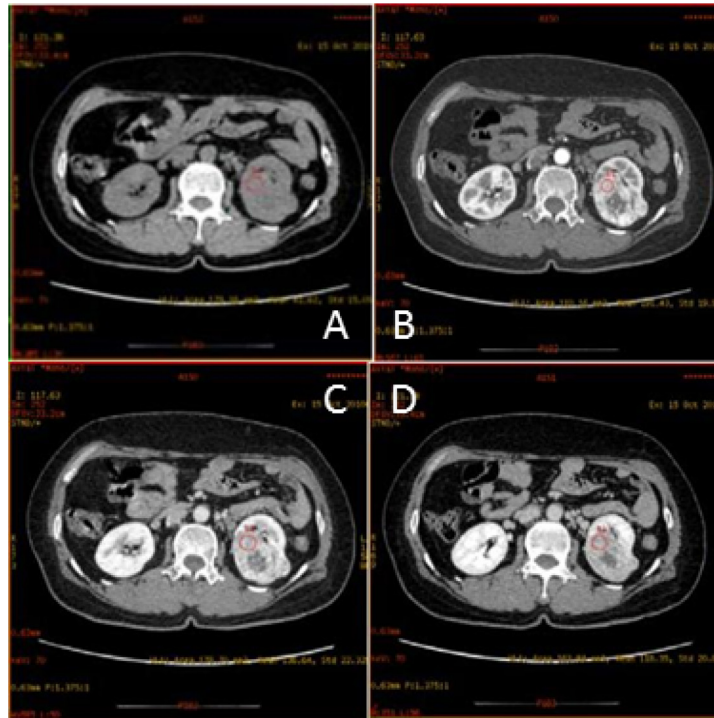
Transverse CT scans of a 51-year old woman with clear cell RCC in left kidney. Shown are (A) unenhanced scan; (B) corticomedullary phase scan showing mass with heterogeneous attenuation and containing no area with attenuation as low as that of perinephric fat; (C) nephrographic phase scan; and (D) excretory phase scan. The red circles are the region of interest (ROI).
